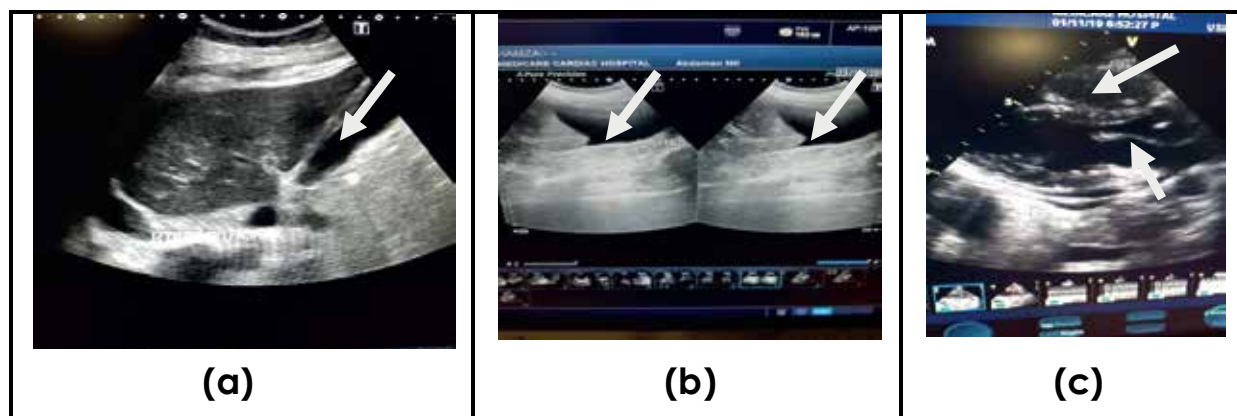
(a) Ultrasound findings of abdomen in patient with dengue fever, arrow show thickened Gall Bladder wall. (b) Ultrasound findings of abdomen in-patient with dengue fever show ascites. (c) Ultrasound findings of thorax inpatient with dengue fever show pericardial effusion.
